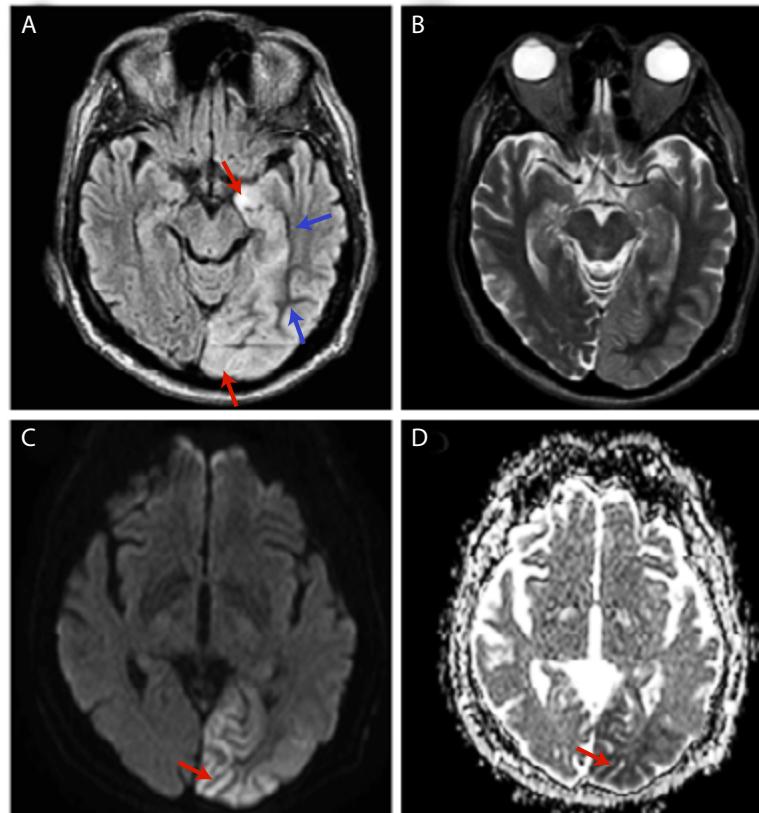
Brain MRI. A-B: FLAIR (T2-weighted-fluid-attenuated inversion recovery) with subcortical low signal (blue arrow) and cortical high signal (red arrow) in occipital-temporal region extending to the left hippocampal gyrus; C-D: Diffusion restriction in left occipital region (red arrow).
